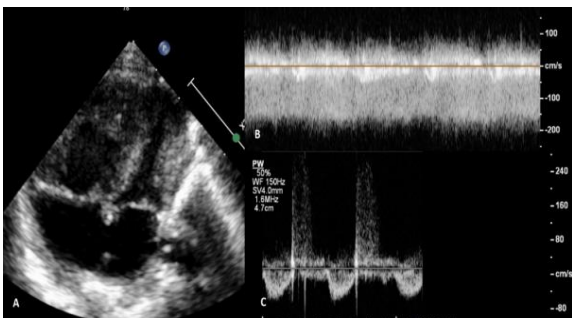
A. Right chambers' dilatation with signs of pressure overload.[\[X1\]](#) B. Pulmonary veins' CW Doppler. C. Pulmonary artery PW Doppler.
